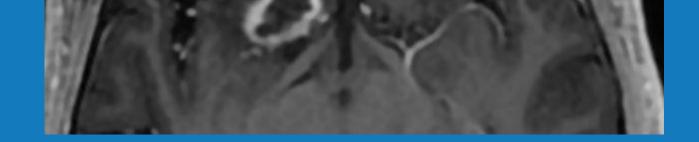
<u>A)</u> Post-operative axial MRI showing the intracranial cuts where the fungus was resected.
